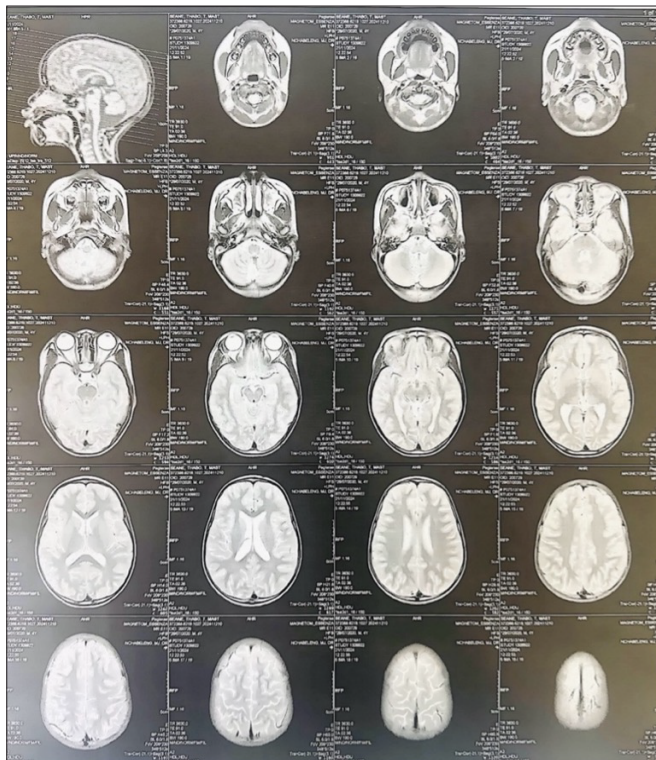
Normal T2-weighted magnetic resonance imaging (MRI) of the brain.
